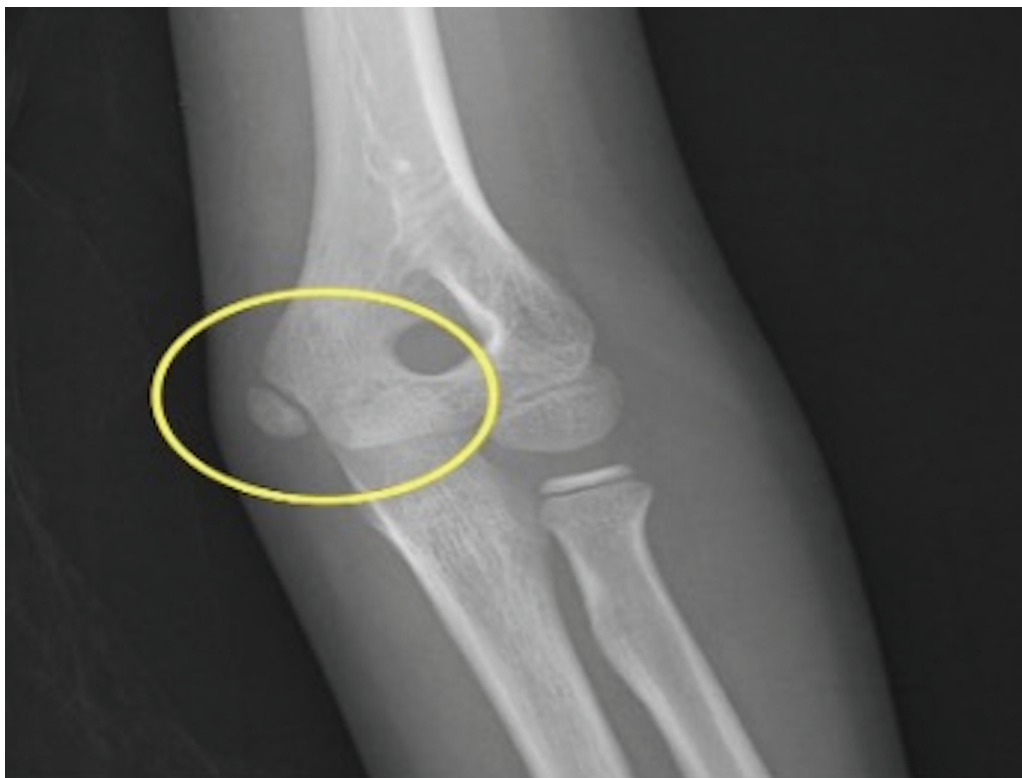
Anteroposterior radiograph of elbow joint of a male child showing appearance of medial epicondyle of humerus (yellow circle) and absence of trochlea indicating age between 7 and 9 years.
